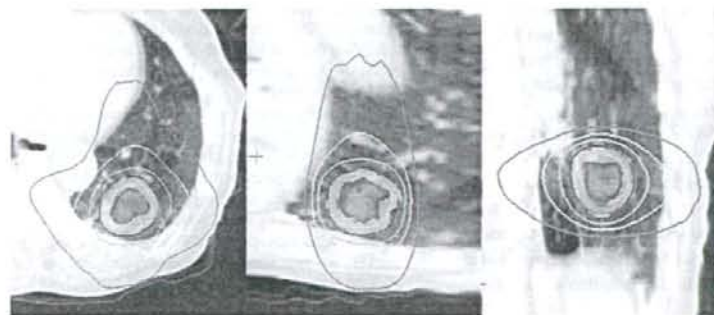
Axial, sagittal, and coronal images of treatment planning computed tomography (CT). The inner area enclosed by a bold line corresponds to the internal target volume (ITV) directly visualized by long-scan-time CT. The outer area enclosed by a bold line corresponds to the planning target volume derived from the ITV and a 6–8 mm margin. The isodose lines from outer to inner represent 20%, 40%, 60%, and 80% of the maximal dose.
